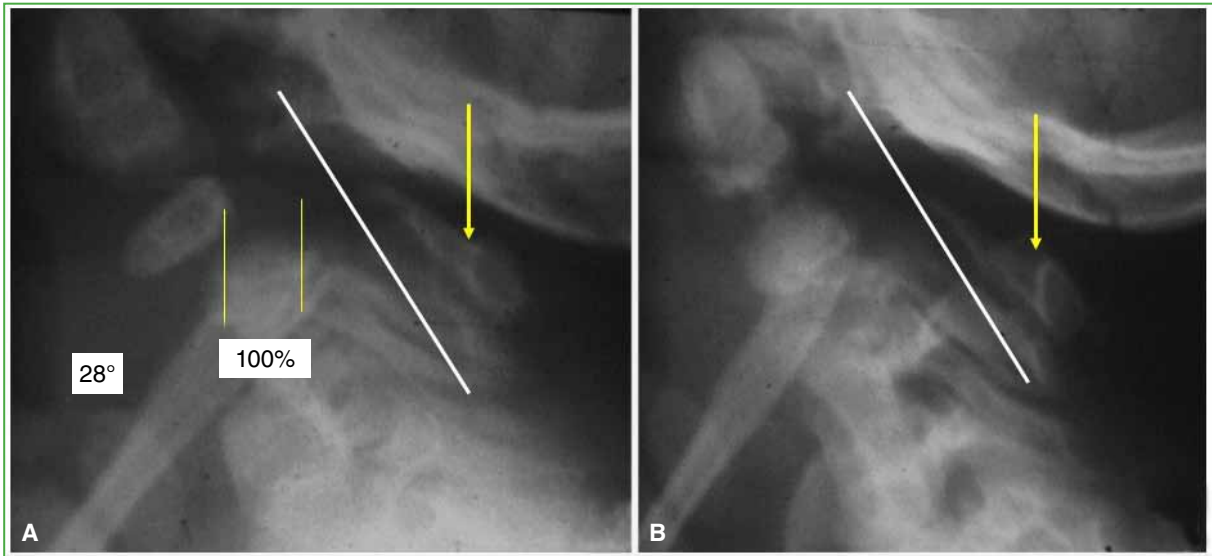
Cervical spine radiograph of a 2-year-old girl following high-energy trauma, showing axis spondylolisthesis without neurological damage. A. The axis spinolaminar cortex is markedly posterior to Swischuk's line (white arrow), with 100% displacement of the C2 vertebra and 28° of kyphosis. B. Post-reduction under general anesthesia with Minerva plaster cast.
